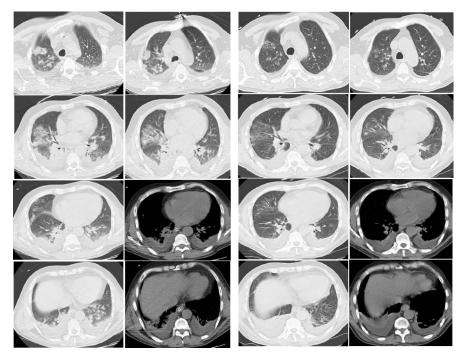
Computed tomography (CT) sections of a patient with ventilator-associated pneumonia characterized by multiple rounded CT attenuations disseminated within right upper lobe and lower lobes. The right image corresponds to day 0 and the left image to day 7. CT at day 0 and 7 are obtained at the same anatomical level according to anatomical landmarks. There is an obvious CT lung re-aeration attesting the efficacy of antimicrobial therapy and characterized by a quasi-complete regression of rounded CT opacities, persisting small pleural effusion and the apparition of a small consolidation in posterior segments of right lower lobe
